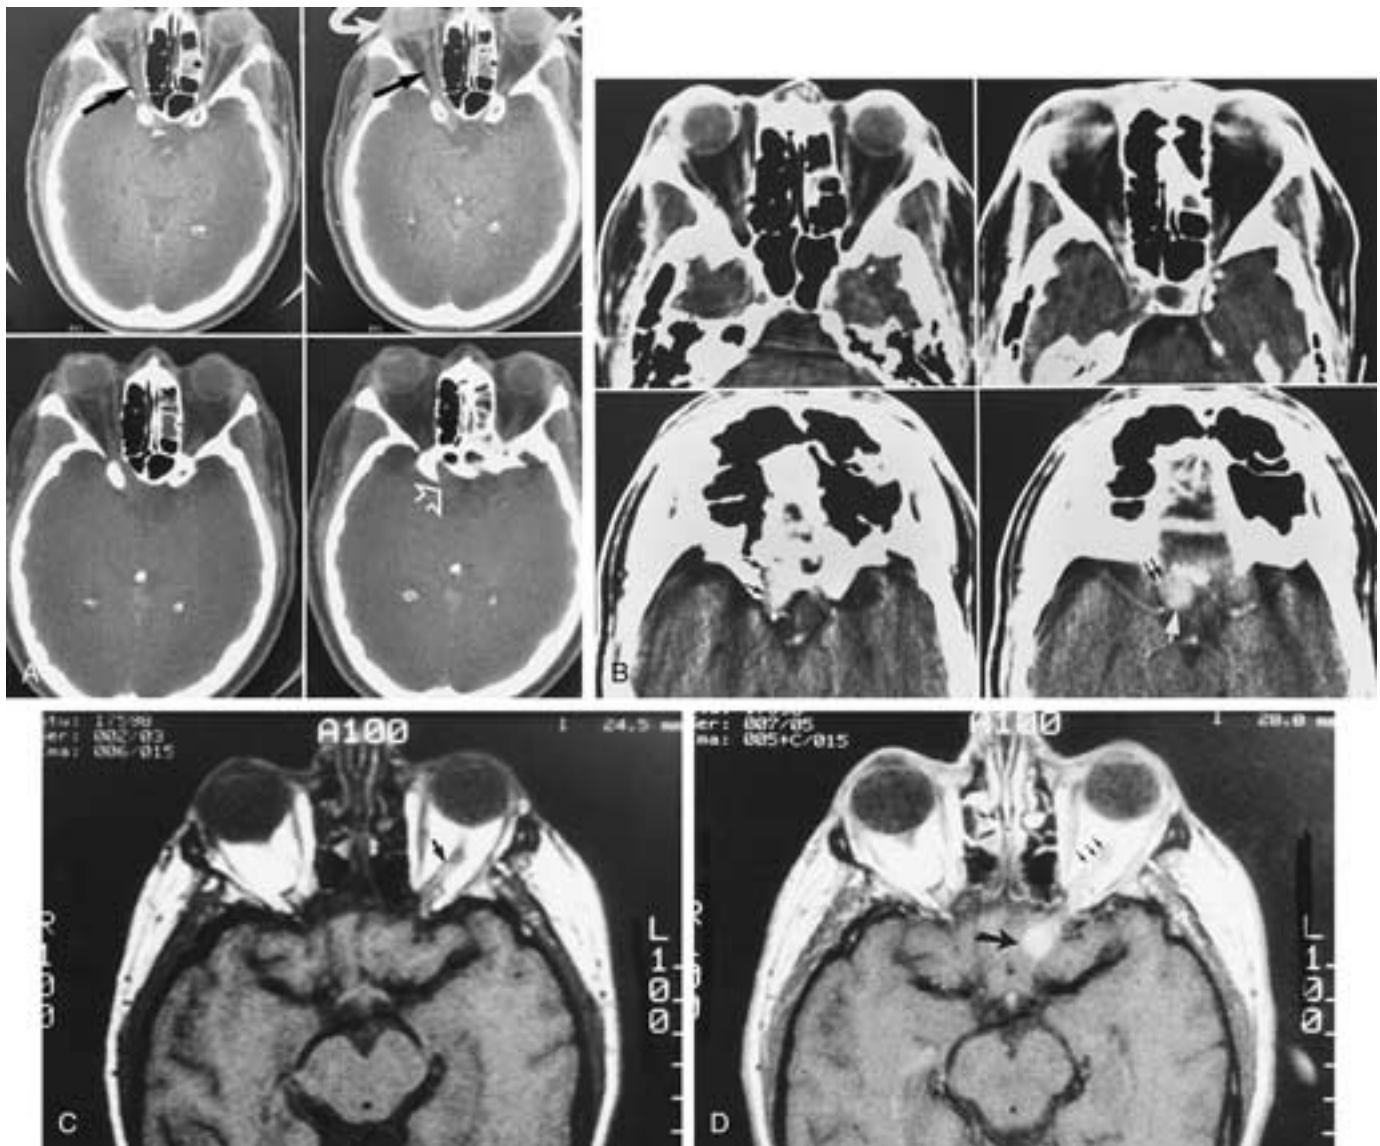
Sarcoidosis with optic nerve involvement. A, Serial axial CT scans show enlargement of the right optic nerve (*arrows*), including its intracranial segment. Note the soft-tissue mass in the right side of the chiasmatic cisterns (*hollow arrow*) and slight bilateral enlargement of the lacrimal glands (*curved arrows*). B, Serial axial CT scans obtained for soft-tissue detail, same patient as in A, show enhancing granulomas (*arrows*). C, Sarcoidosis-granuloma of the optic nerve. Axial T1-weighted MR scan shows no obvious lesion. There is a suggestion of slight thickening of the left optic nerve (*arrow*). D, Sarcoidosis-granuloma of the optic nerve. Enhanced axial T1-weighted MR scan shows increased enhancement of the left optic nerve (*arrows*) and a large granuloma involving the intracranial segment of the left optic nerve (*single arrow*).
